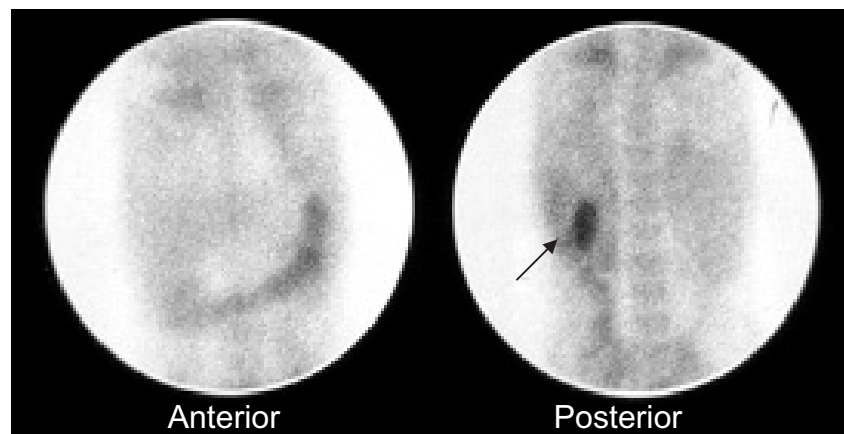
Indium-111-labeled leukocyte study (a) shows a large acute abdominal abscess (arrow) corresponding to the finding (arrow) on CT (b)
